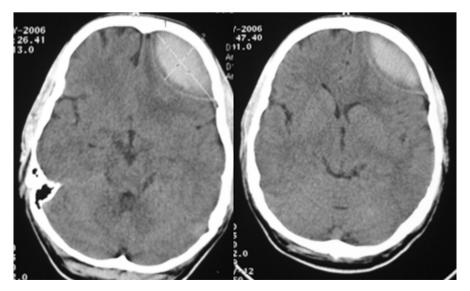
CT scan showing large left frontal extradural haematoma with thickened dura, perilesional oedema, mass effect and midline shift.
